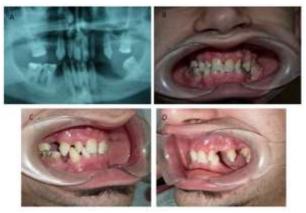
A, Panoramic radiograph of proband shows congenital teeth absence. B, C and D, Clinical aspects of oral and dental status.
